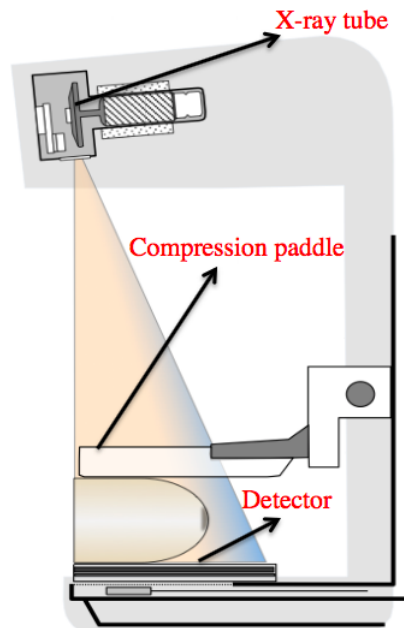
Clinical mammography set up: the x-ray are emitted from an x-ray tube towards the breast. The breast is compressed by a compression paddle and the image is recorded by a detector (courtesy of J.M. Boone presentation).
